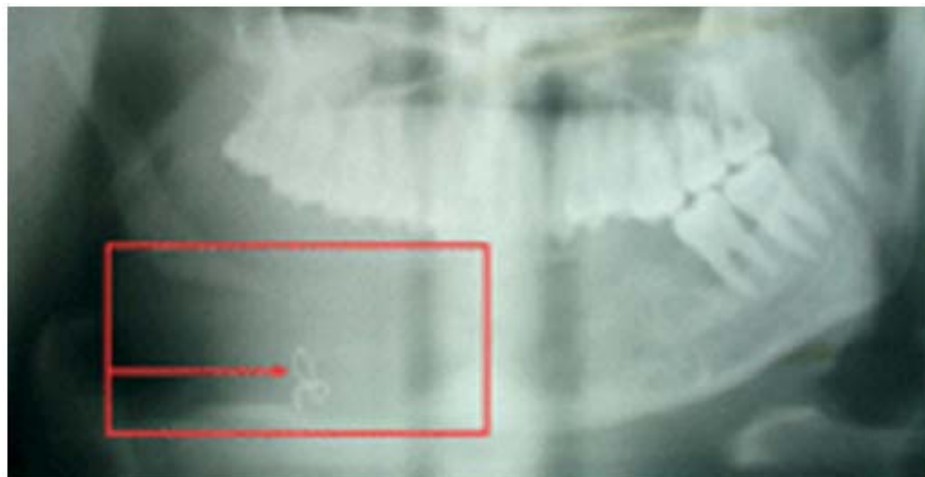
Panoramic radiograph taken 3 months after initial panoramic radiograph showing progressive resorption of right mandibular body and loss of bone, encroaching on mandibular canal space.³¹
